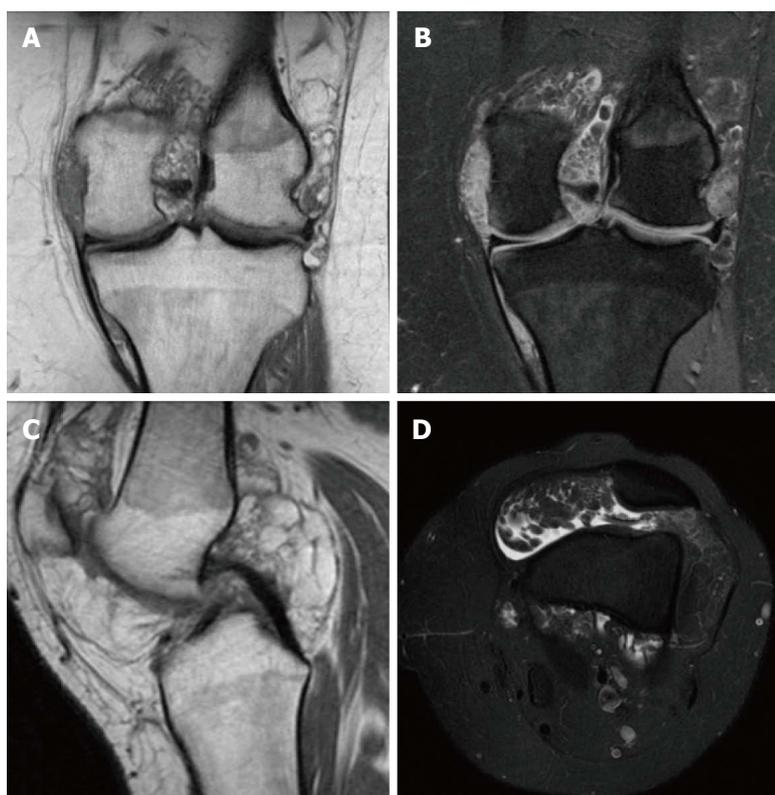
Left knee magnetic resonance imaging demonstrating effusion in the suprapatellar bursa and hypertrophic synovium with leaf-like projections of tissue which has the same signal intensity as fat. A: Coronal proton density (PD); B: coronal PD fat saturation; C: Sagittal PD; D: Axial T2 fat saturation.
